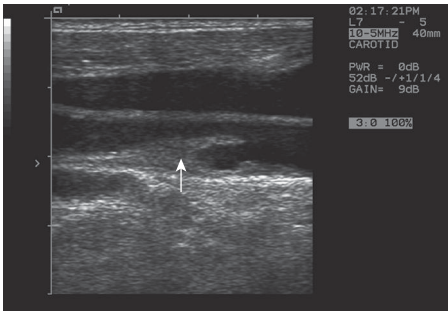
Picture of an irregular plaque on B-mode ultrasound (arrowed). © Hugh Markus.
